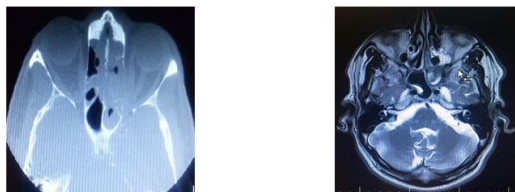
(left): The axial PNS CT scan demonstrating dehiscence left lamina papyracea posteriorly as noticed during operation.
